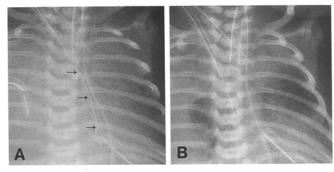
A Chest radiograph following left CDH repair demonstrated shift (arrows) of mediastinal cannulae to the left. B Right chest tube resulted in development of a right hemothorax
